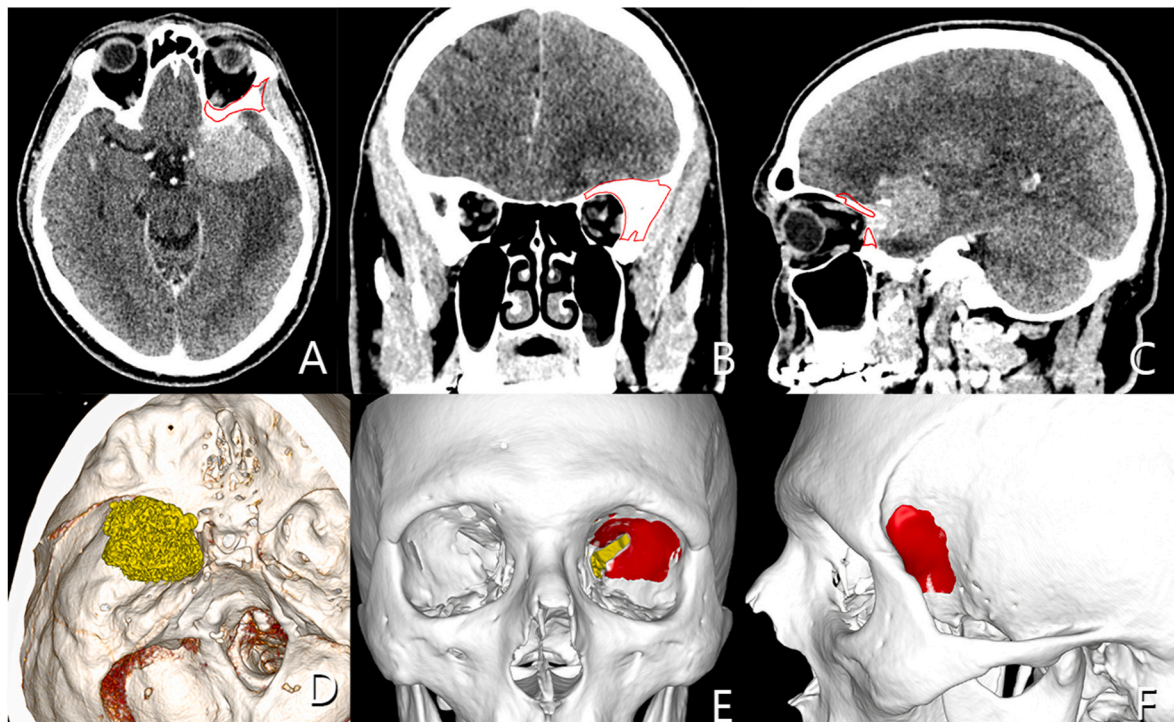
Patient 1. (A–C) Pre-op CT scan, extent of hyperostosis. (D–F) 3D CT scan, intradural tumor soft component (yellow), extent of hyperostosis (red). (For interpretation of the references to colour in this figure legend, the reader is referred to the web version of this article.)
